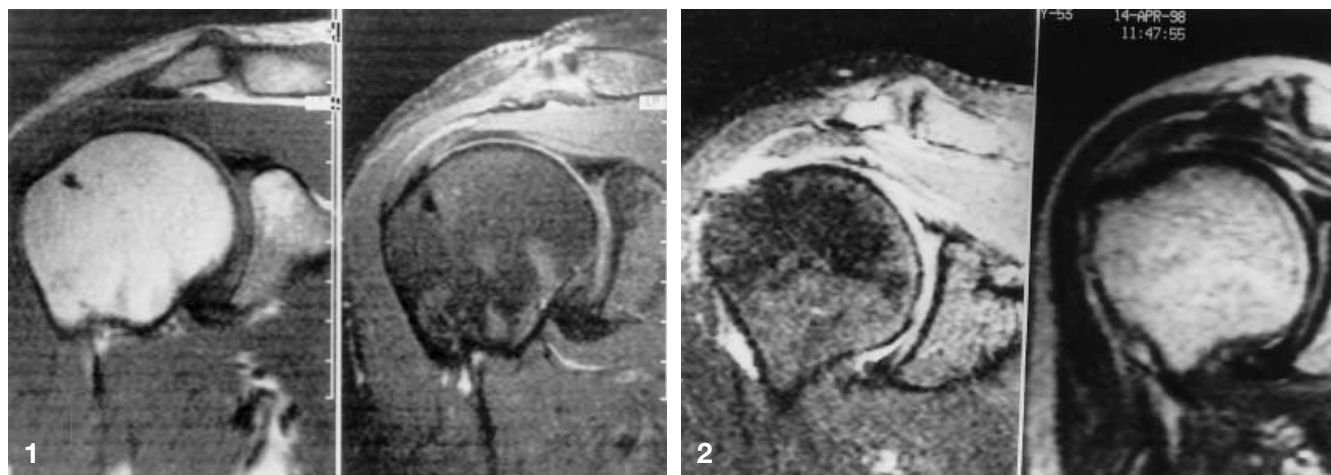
Comparison of paracoronal T1-weighted SE (*left*) and fat-saturated T1-weighted post-contrast spin-echo (*right*) images. Anatomic contour delineation is superior on fat-saturated T1-weighted post-contrast image as compared with the image without fat suppression and contrast injection. Note contrast accumulation in subdeltoid bursa and glenoid cavity at right image
